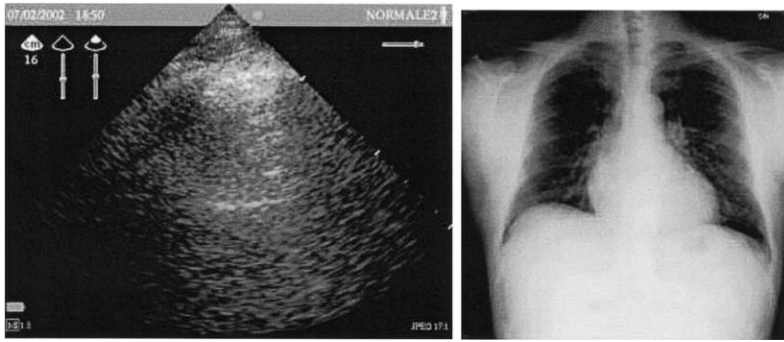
Echographic view of the lung (left) and chest x-ray (right) of a patient without extravascular lung water.
